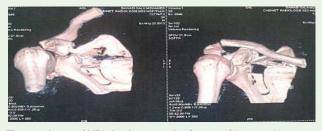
Image of MRI showing a complex fracture of the scapula.
